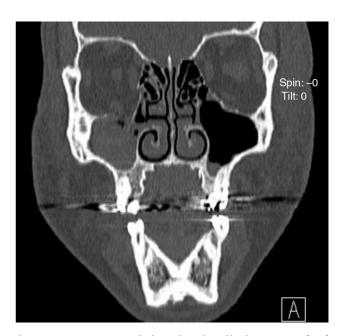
CT scan: coronal view showing displacement of soft tissue within the maxillary sinus.
